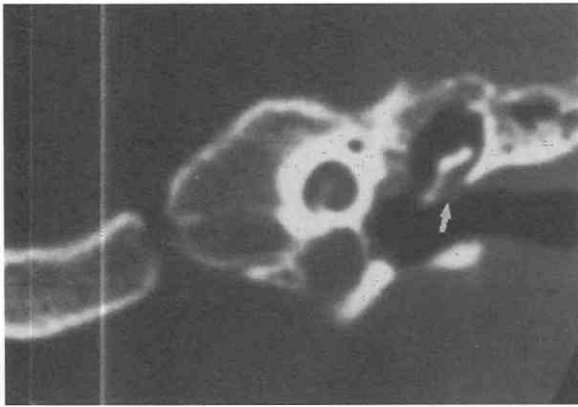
Small early cholesteatoma. Coronal CT scan of the left temporal bone shows a small soft tissue mass (arrow) just lateral to the malleus and medial to the scutum. There is no bone destruction. This is consistent with an early deformity of the pars flaccida and a cholesteatoma.
